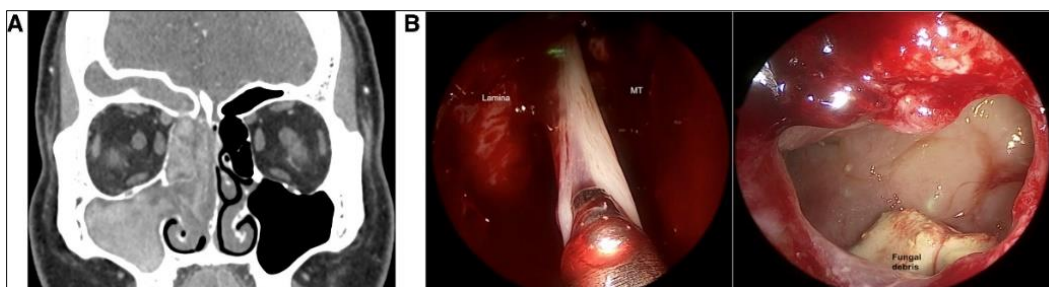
CT images of allergic fungal rhinosinusitis. (A) Coronal post-contrast soft tissue window computed tomography shows unilateral involvement of all sinuses on the right side. It appears to be diffuse within the right maxillary and frontal sinuses and the ethmoid. There is mild expansion of the ethmoid and frontal sinuses with bony remodeling. (B) The endoscopic image shows allergic or eosinophilic mucin originating from the right frontal sinus, and the intraoperative endoscopic image of the right maxillary sinus after antrostomy shows fungal remnants. Lamina, lamina papyracea; MT, middle turbinate⁵
